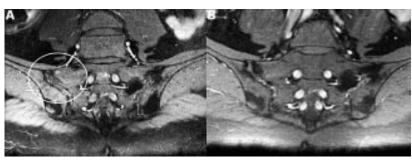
Gadolinium contrast enhanced T_i weighted magnetic resonance imaging before treatment with infliximab (A) showing contrast enhancement in the right ileosacral joint, and (B) in week 41 of treatment showing no contrast agent uptake.
